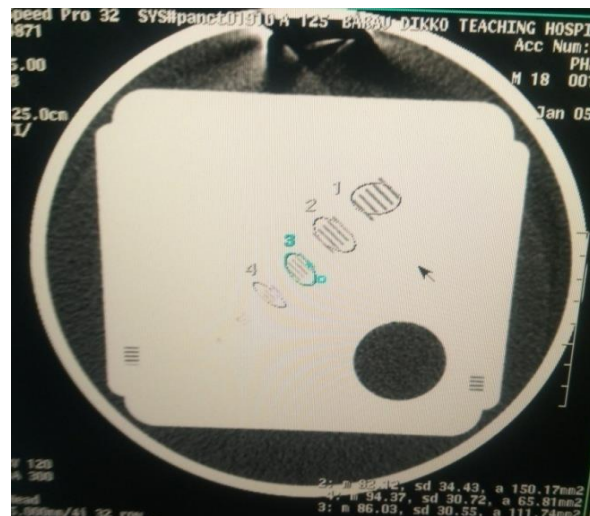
Scanner I CT QC image for high contrast resolution
